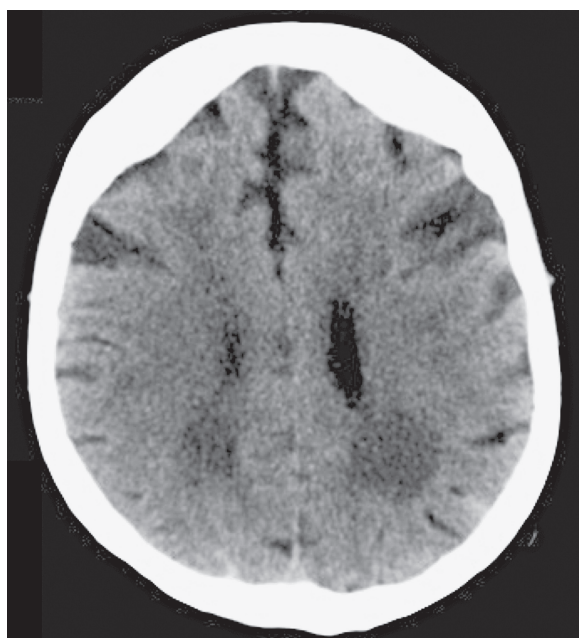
Non-enhanced head CT scan. Axial slice at the level of the corona radiata show hyperdense occupation of cortical parietal sulci, corresponding to SAH. No other anomalies were seen in the remaining study, including and intracranial CTA (not shown).
